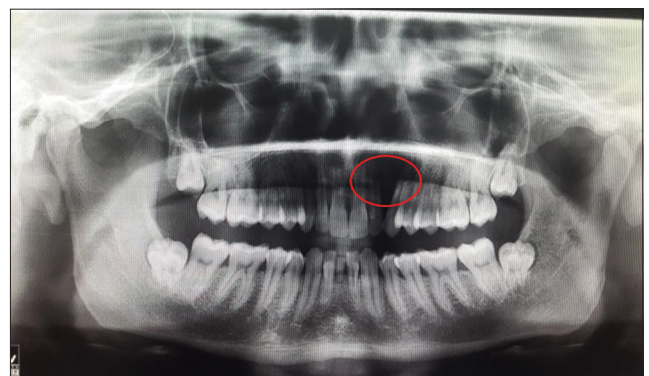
Orthopantomogram showing diffuse radiolucency in relation to 22 and 24
